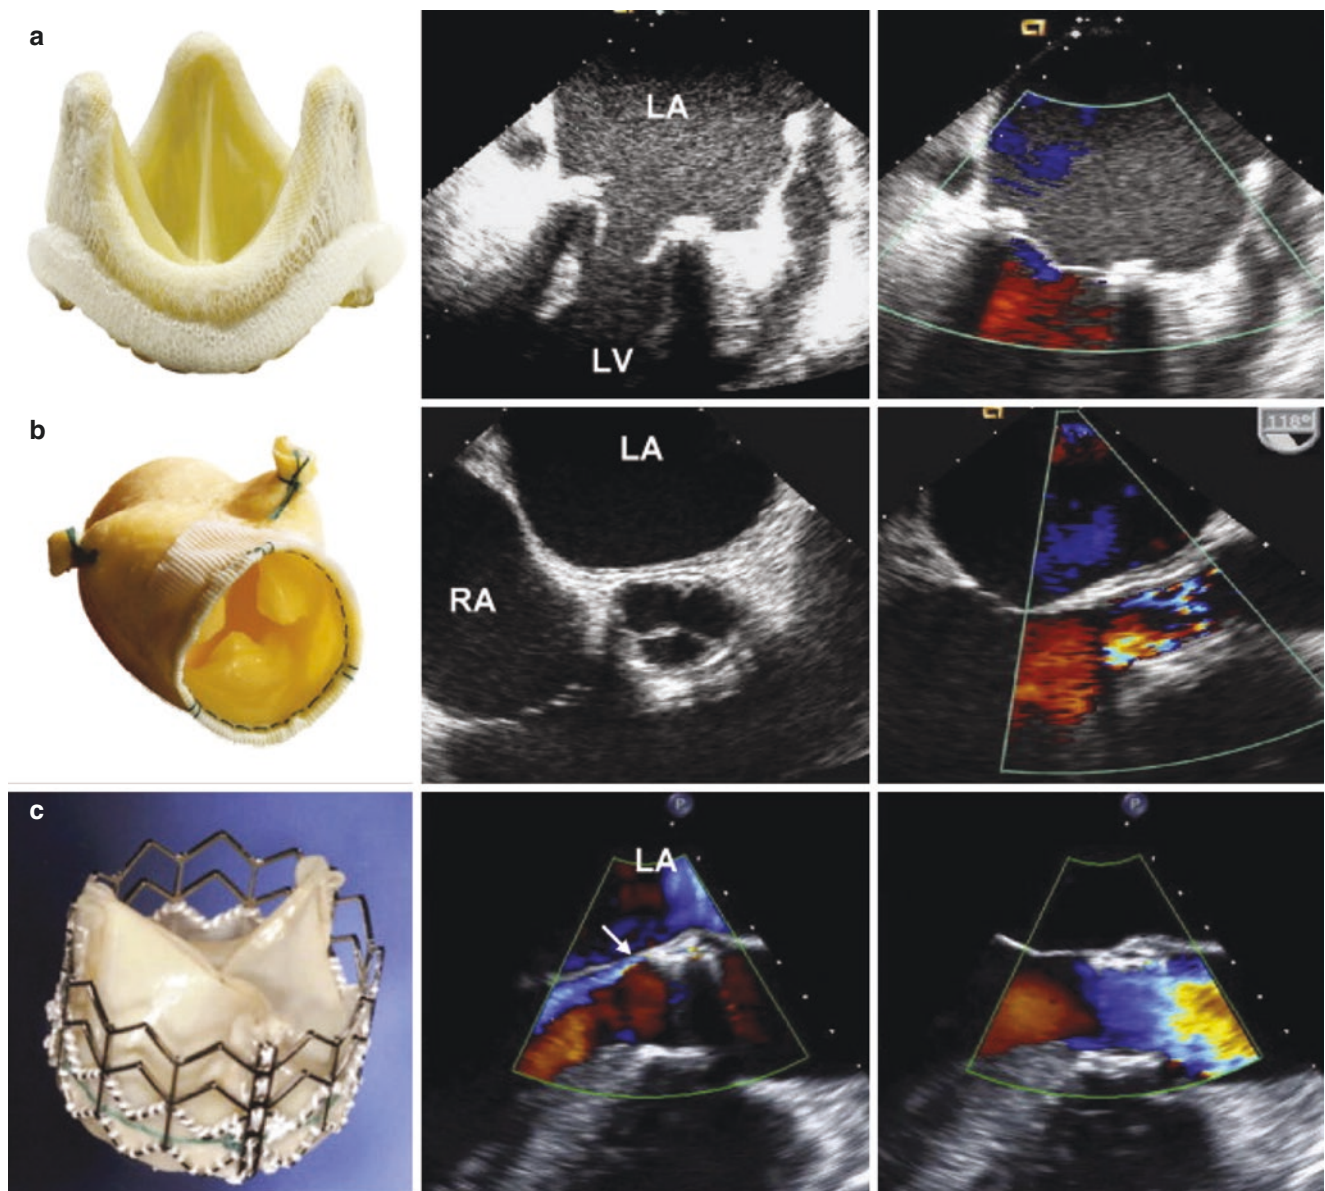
Examples of stented (a), stentless (b), and percutaneous biologic valves (Edwards SAPIEN, c) and their echocardiographic features in diastole (middle) and in systole (right) as seen by TEE. The
